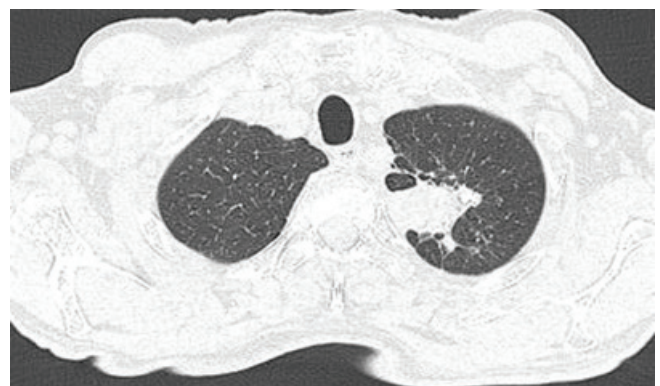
Thoracic CT transversal section showing a solitary pulmonary mass in the upper left lobe.
